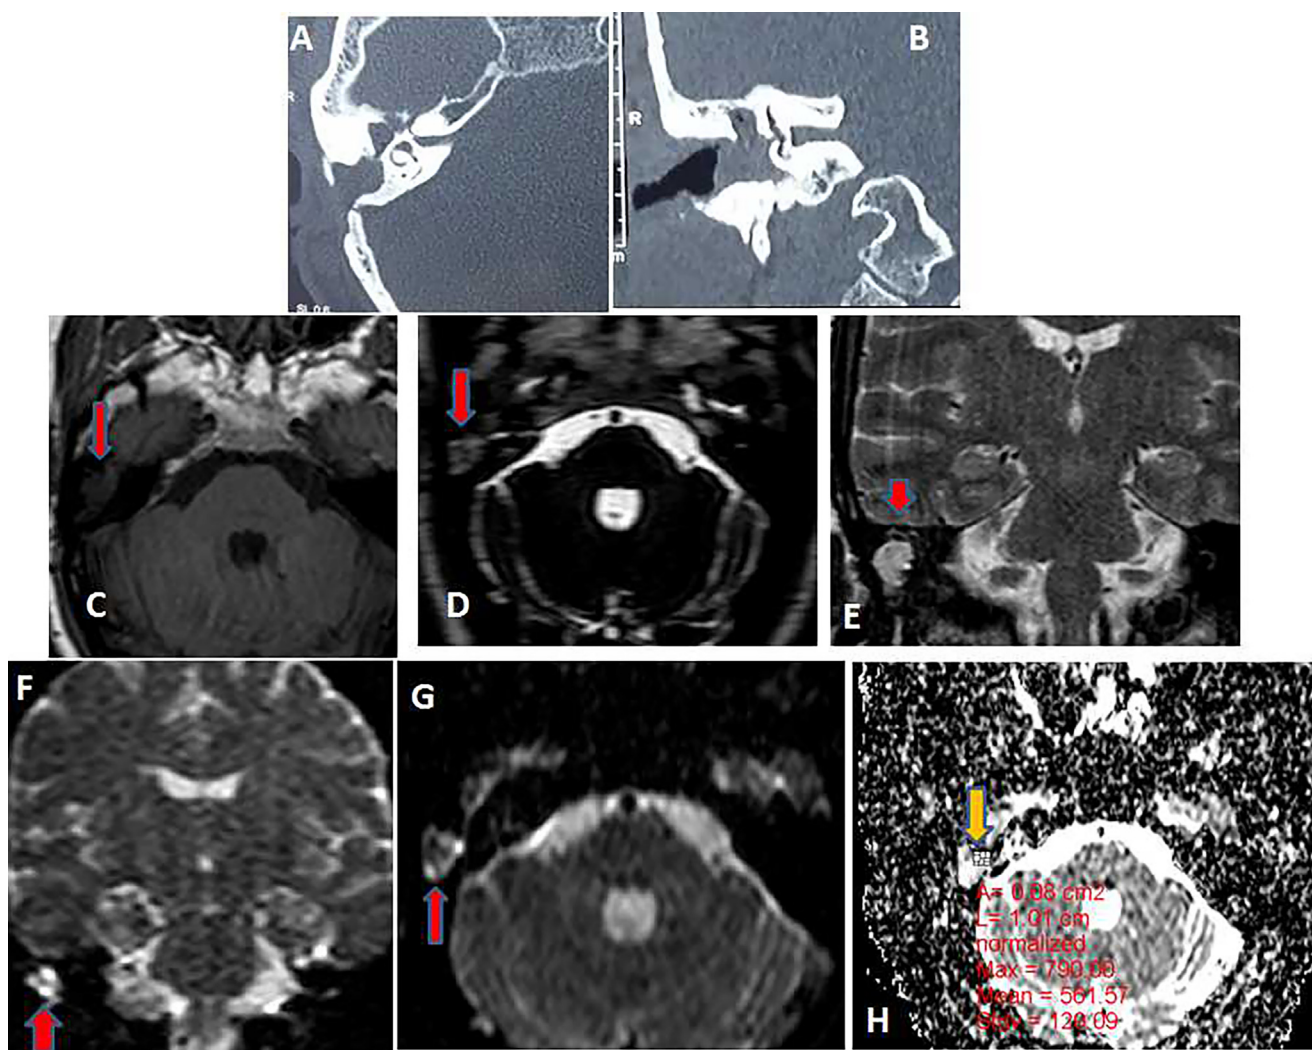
Recurrent cholesteatoma in the right middle ear of 45y old woman who underwent CWU middle ear surgery. (A and B) Axial and coronal CT cuts showed complete opacification of the right middle ear cleft by tissue density lesion associated with eroded ossicular chain and bulging tympanic membrane outwards. (C) Axial T1WI, (D) Axial CISS and (E) Coronal T2W conventional non contrast MRI showed a soft tissue lesion in the right middle ear cleft of hypointense signal at T1WI and high signal intensity in T2WI and CISS. (F, G) Coronal and axial diffusion-weighted fast SE image obtained with a b factor of 1000 s/mm^2 showed high signal intensity of the cholesteatoma. (H) ADC (mean $561.75 \times 10^{-3} \text{ mm}^2/\text{s}$). The lesion size is 1.5 cm at CT and 1 cm at DWI.
